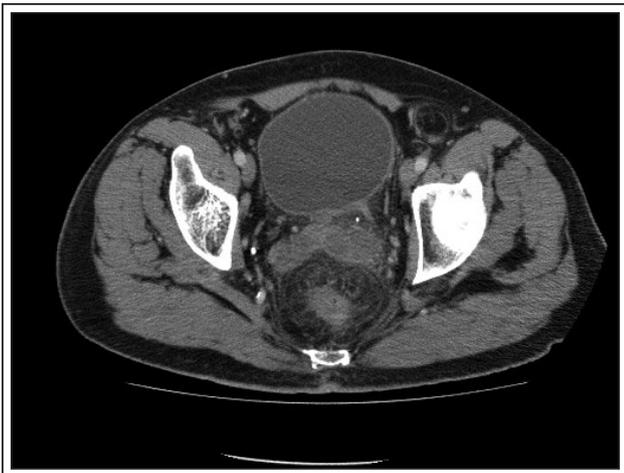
Axial computed tomography of abdomen and pelvis with oral and intravenous contrast. Mild left seminal vesicle (SV) enlargement compared to right with soft tissue stranding around prostate and SVs. No discrete fluid collection identified.
